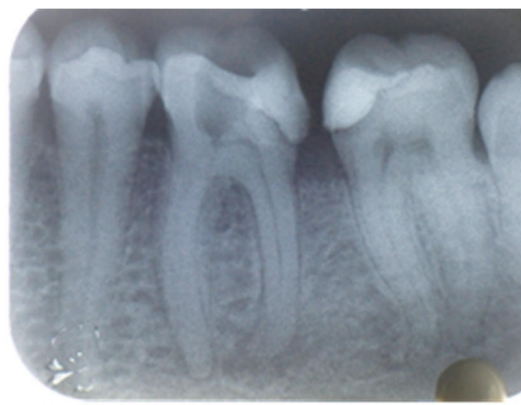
Target X-ray image of tooth 46 in the patient. The condition of the tooth within 9 months after treatment.
